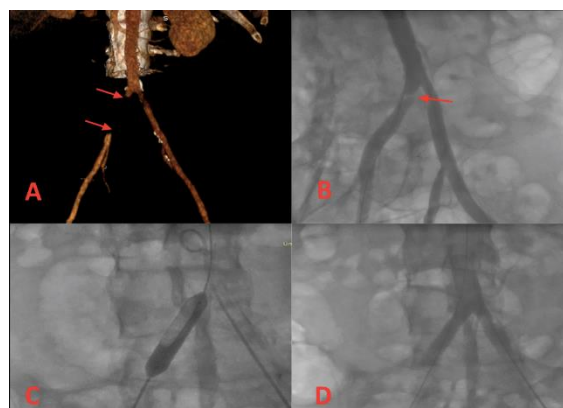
A; Diagnostic imaging of aortic and iliac arteries using contrast enhanced multi-slice computed tomography. B; Spiral dissection of common iliac artery was shown using peripheral artery angiography. C; Implantation of peripheral stent. D; The angiographic image of the iliac artery after the deployment of the peripheral stentouter diameter with surrounding inflammation and hyperemia anemia in the form of schistocytes and polychromasia
